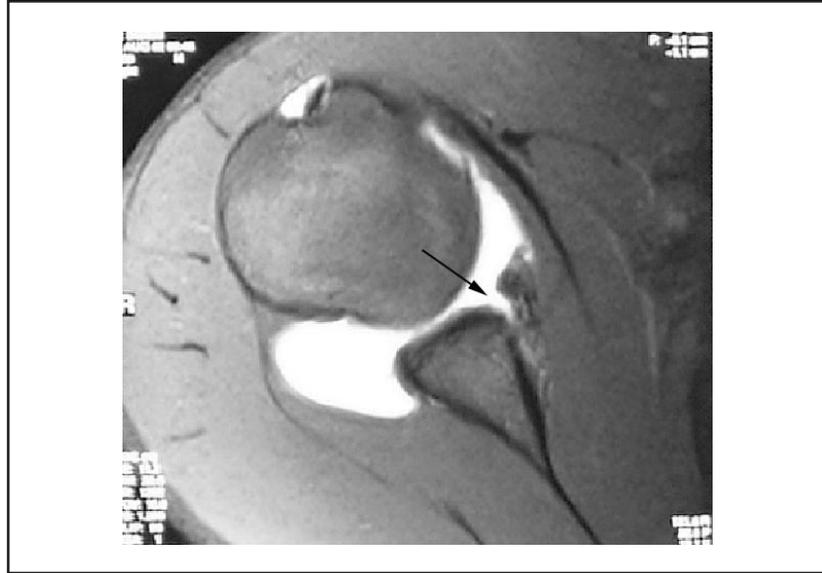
Shoulder MR arthrogram. Axial fat suppressed T1 fast-spin echo MR sequence demonstrates Bankart lesion in patient with normal radiographs, but clinical signs of anterior instability.
